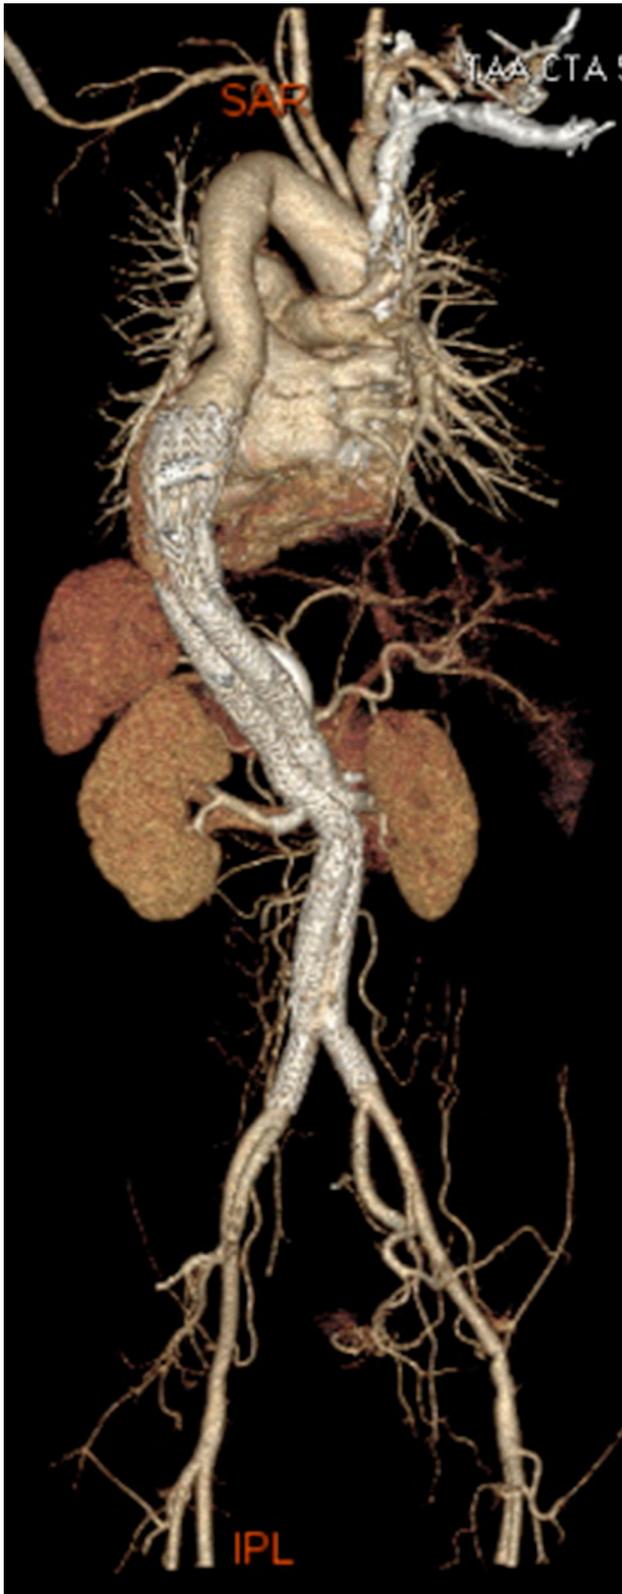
Three-dimensional reconstruction of computed tomography angiography of the aorta. No endoleaks were observed, and all visceral arteries were patent
